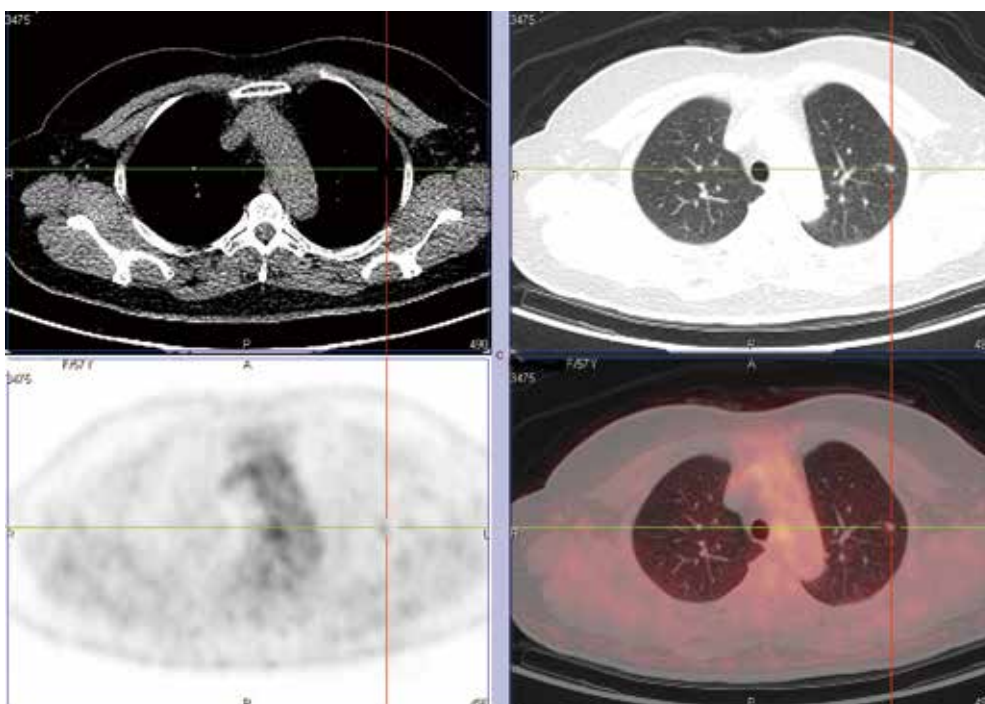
PET-CT shows a case of atypical adenomatous hyperplasia with a SUVmax of 1.42.
